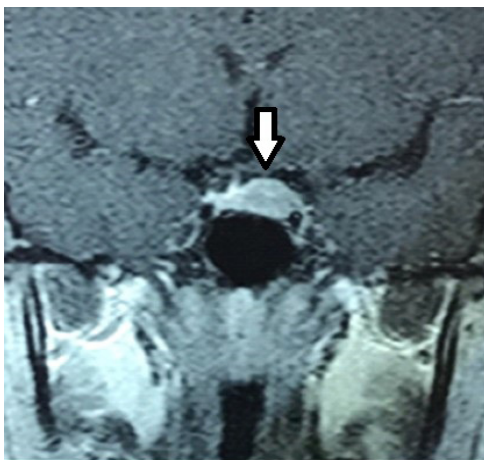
Pituitary gland MRI at diagnosis showed a suprasellar mass (arrow)
